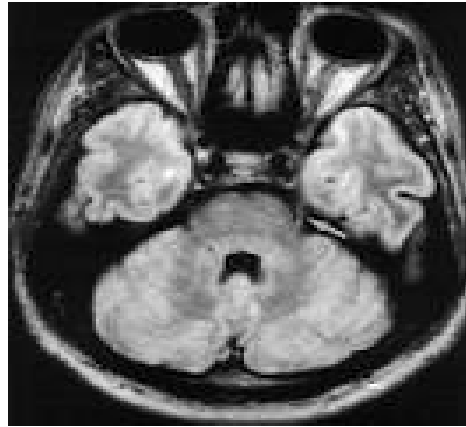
Axial MRI T2 shows temporal lobe
